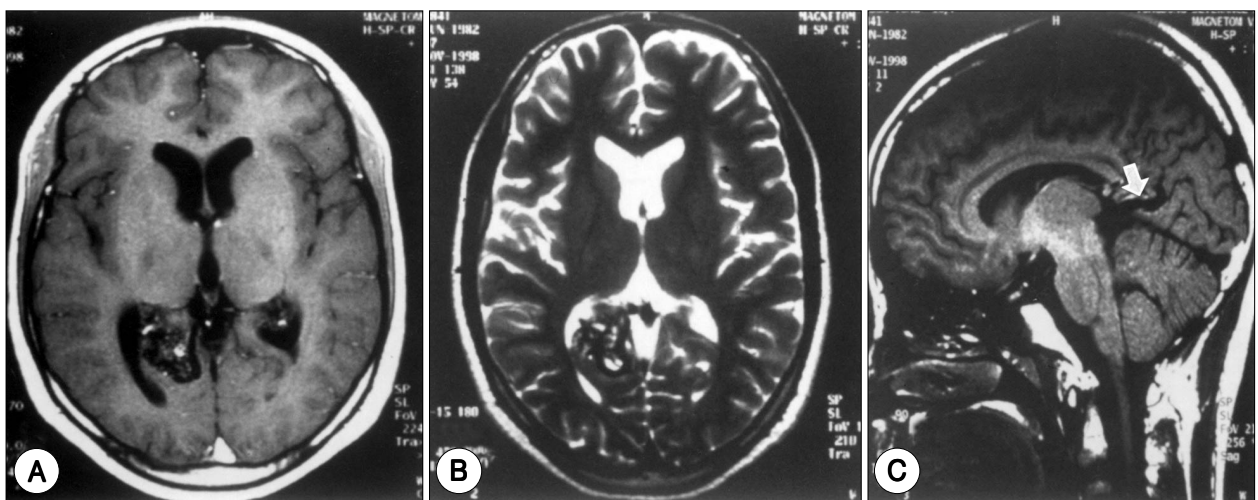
T₁(A) and T₂(B) weighted magnetic resonance images revealing an arteriovenous malformation on the parasplenial-subtrigonal area. Sagittal image shows venous drainage(white arrow) toward the junction of parietooccipital and calcarine sulcus(C).
